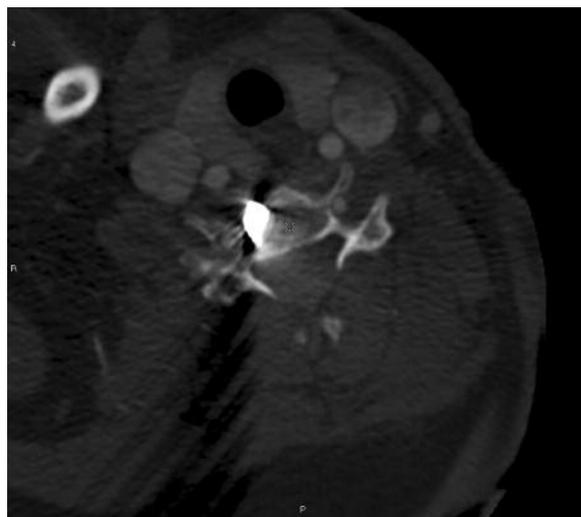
CT scan demonstrates apex of the knife near the right vertebral artery.
